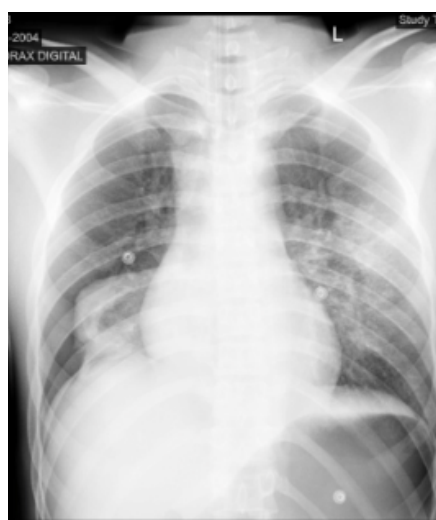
Chest X-ray showing bilateral pulmonary contusion upon hospital admission.
